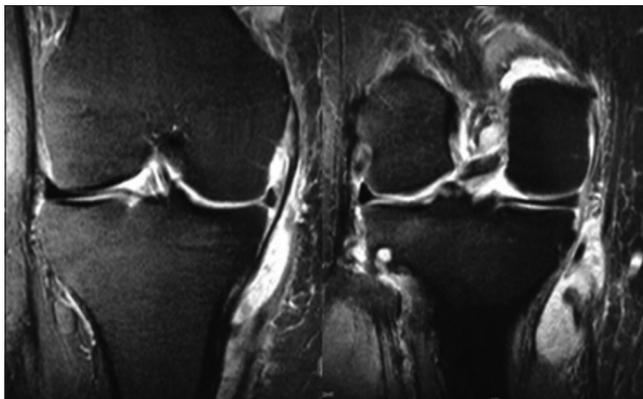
Coronal short tau inversion recovery magnetic resonance images of the knee demonstrate a fluid collection with surrounding edema (white arrow) just deep to the pes anserine and superficial to the medial collateral ligament in keeping with pes anserine bursitis.
